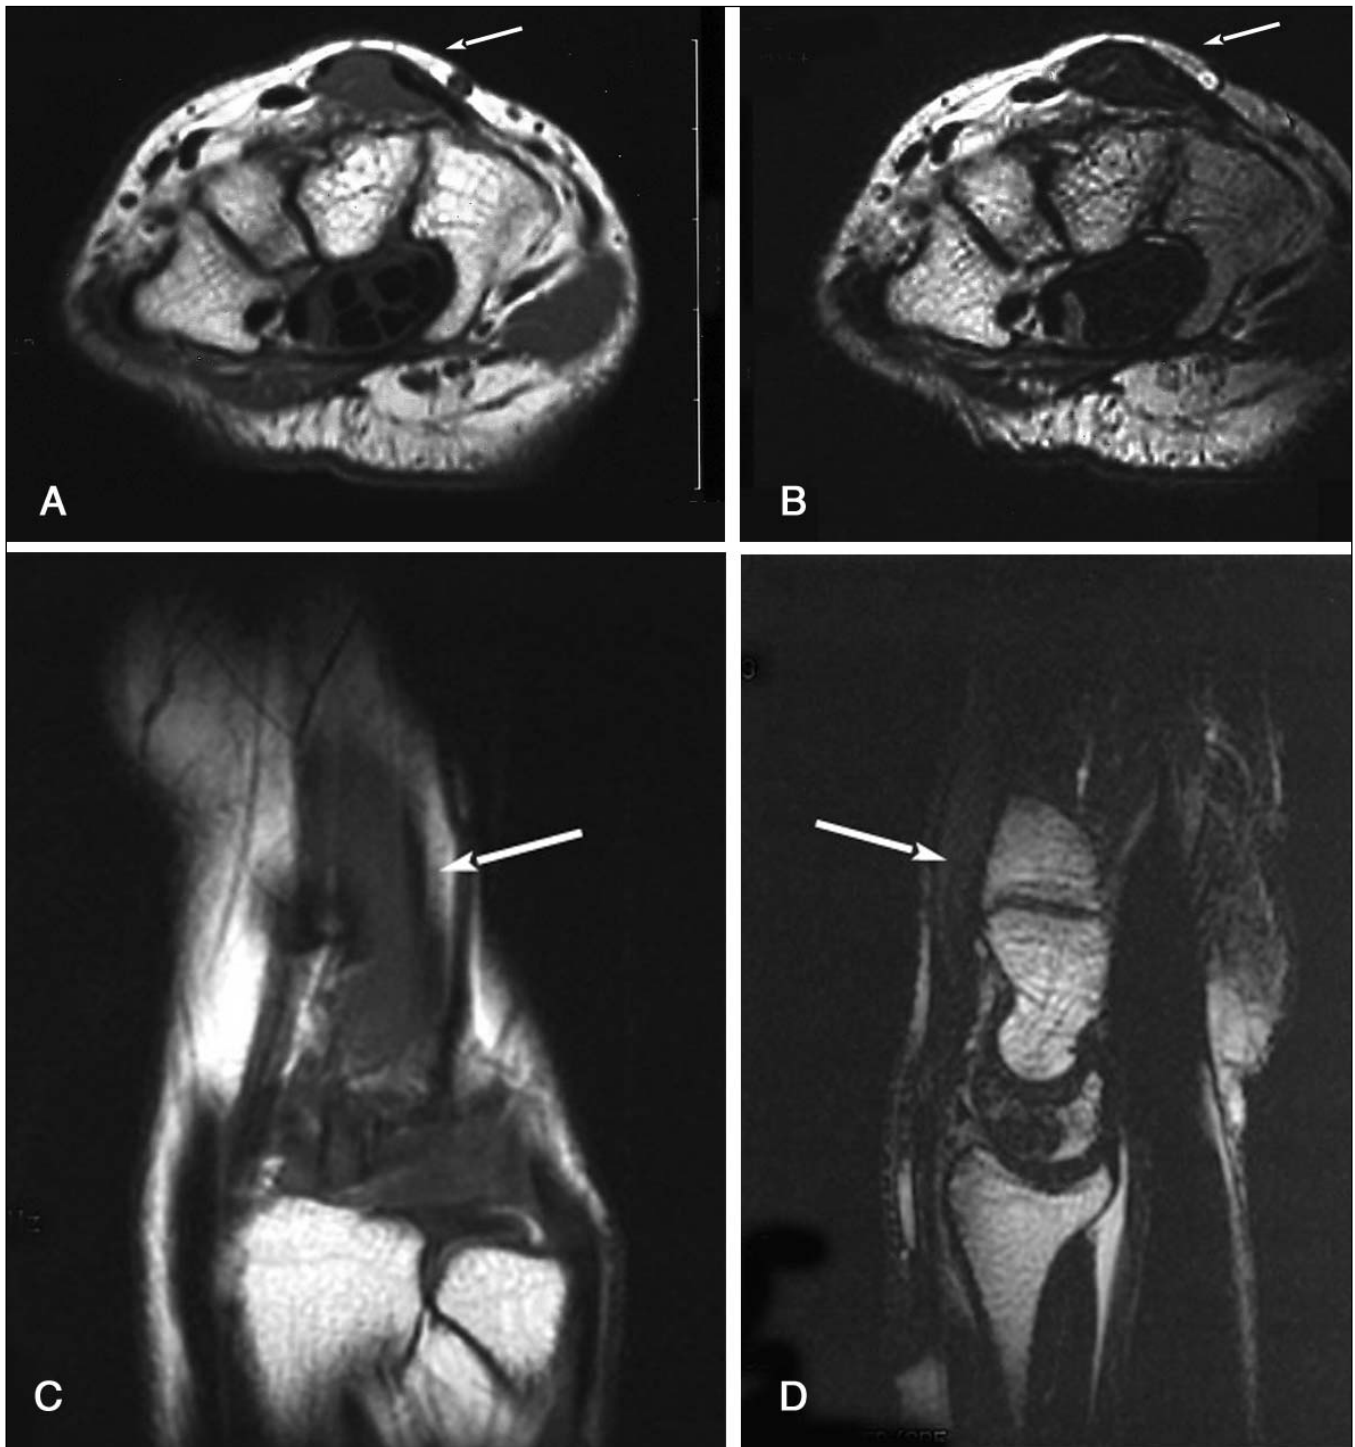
Axial T1 (A) and Axial T2 (B) magnetic resonance imaging (MRI) of the left wrist, at the same level at the computed tomography (CT). Confirms that the 'mass-like' area is iso-intense with surrounding muscle and has a characteristic appearance and location of an anomalous muscle (white arrow); Coronal T1 (C) and Sagittal T2 (D) MRI of the left wrist, at the same level at the CT. Confirms that the 'mass-like' area is iso-intense with surrounding muscle and has a characteristic appearance and location of an anomalous muscle (white arrow)
